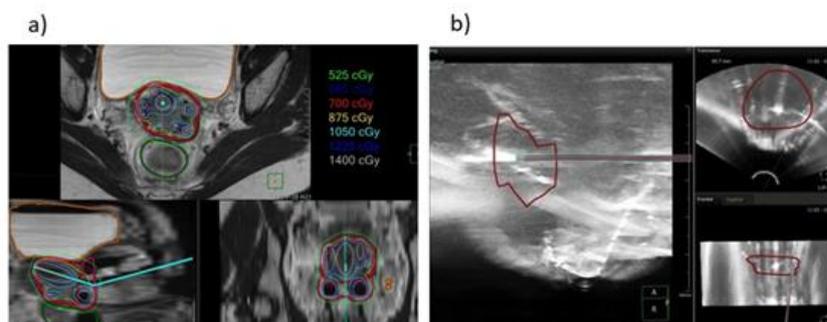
A pre-plan was made based on the MRI image set and contours (a). The implant was then reproduced in water. The insertion guidance was based on the MRI delineated target and pre-plan (contour in red). The needle was tracked real time using the EM tracking system and the US system. The tracked needle is shown and the automatic reconstructed needle fits with the US scan (b).
